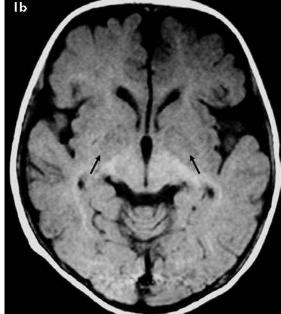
I (a) Axial T2WI MR image shows bilateral symmetrical hyperintensities in both globus pallidi (black arrows) and increased perisylvian and fronto-temporal extra axial cerebrospinal fluid spaces (white arrows). (b) Axial T1WI MR image shows mild hypointensity (arrows) noted in the globus pallidus on both sides.
